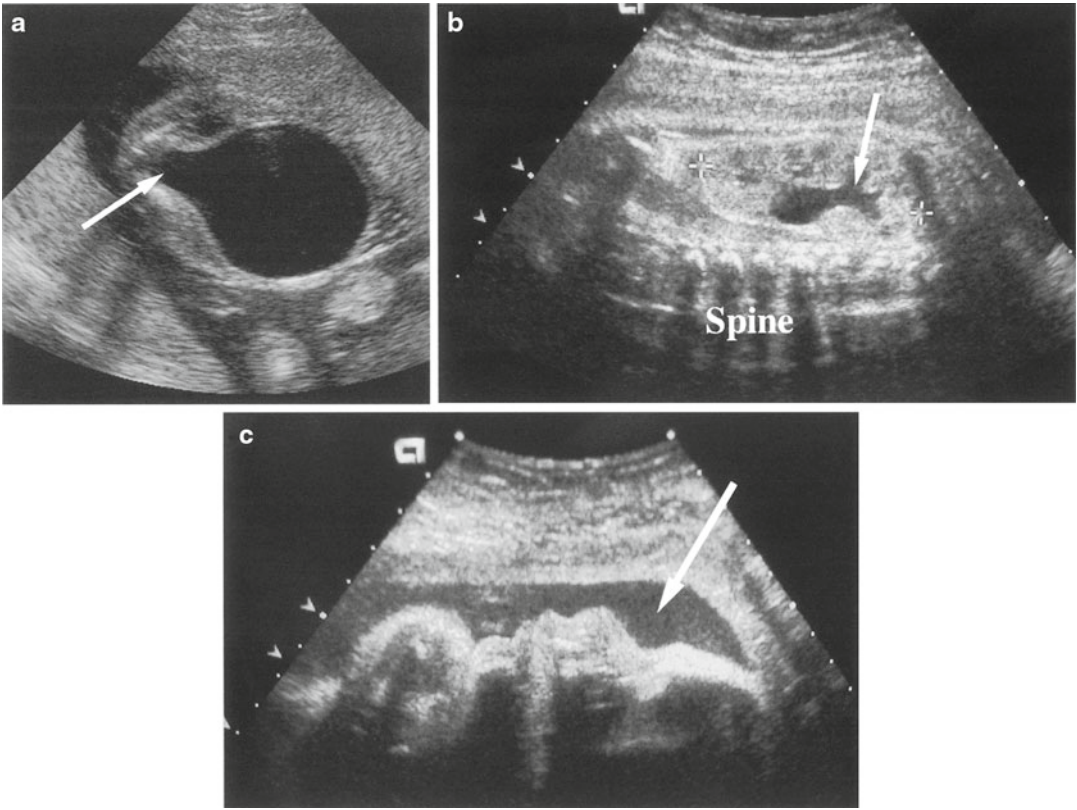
Ultrasound of a fetus at 30 weeks gestation with PUVs. (a) Note the dilated bladder and posterior urethra (arrow). There is associated (b) hydronephrosis (arrow) and (c) oligohydramnios (arrow)
